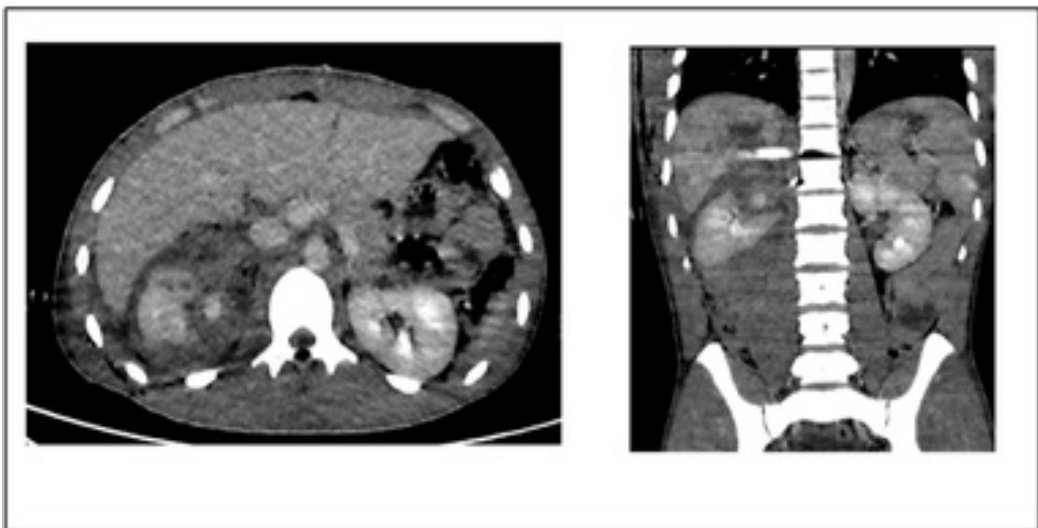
Contrast-enhanced abdominal computed tomography demonstrating a grade IV renal injury according to the WSES-AAST classification.
